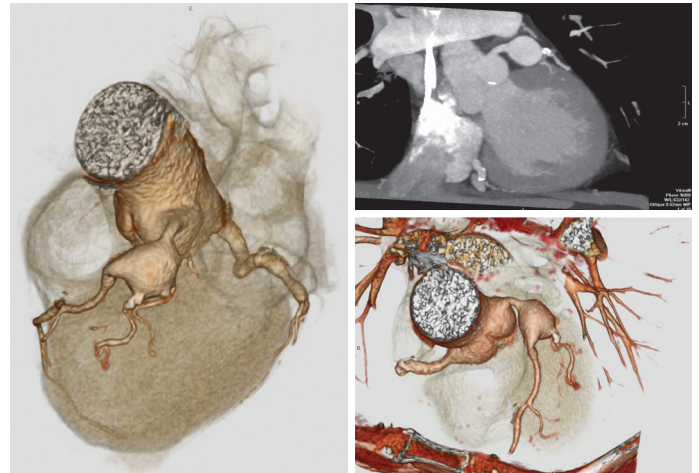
Computed tomography coronary angiography was showed 2.0×2.0 mm saccular aneurysm at the bifurcation of LAD.
